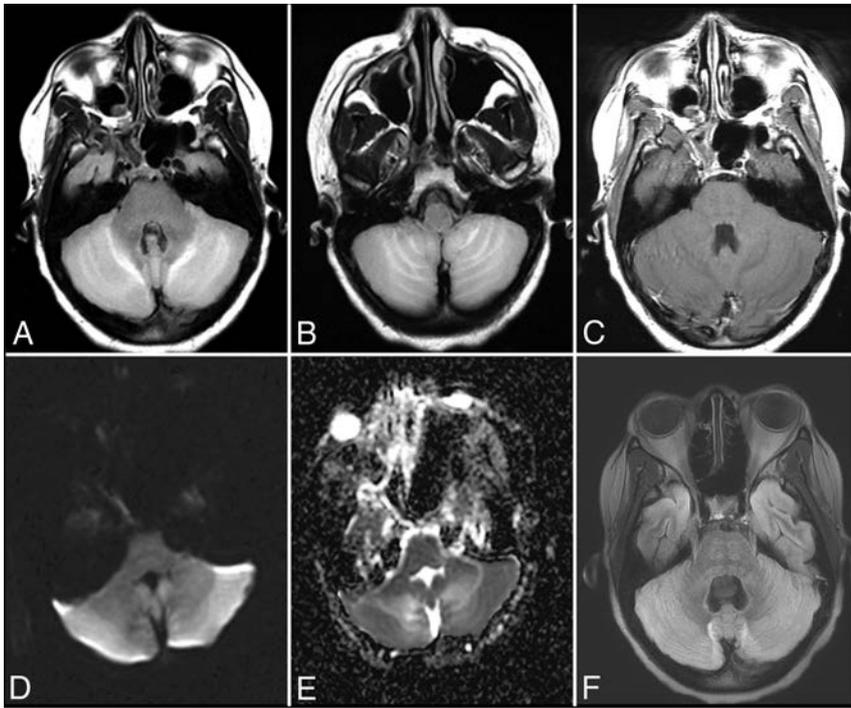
Anti-voltage-gated calcium channel cerebellitis. A 23-year-old woman with a history of autoimmune hepatitis presented with altered mental status. Initial brain MR imaging (A–E) demonstrates T2-FLAIR hyperintensity within the bilateral cerebellar hemispheres with mass effect on the fourth ventricle (A and B), without evidence of postcontrast enhancement (C) and with mild restricted diffusion on DWI (D) and the corresponding ADC map (E). A follow-up scan 1 month later (F) demonstrates resolution of the T2-FLAIR hyperintensity and associated mass effect on the fourth ventricle following a steroid taper.
